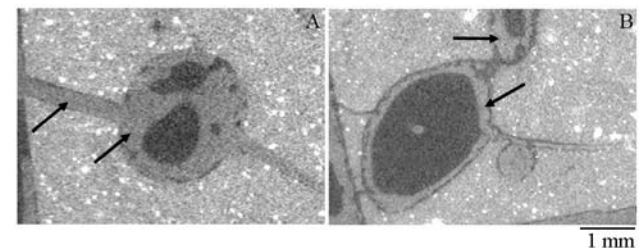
2D μ CT images at A. 6 months and B. 60 months. Arrows denote newly formed bone within the PCL.
